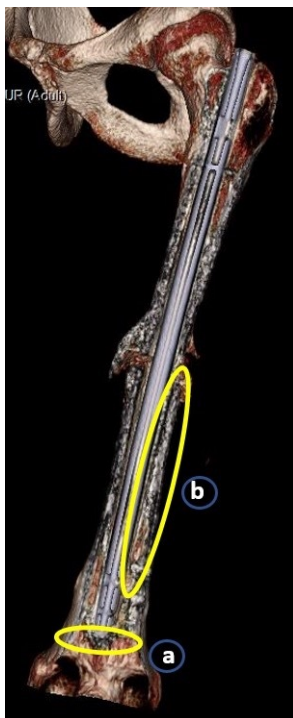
a- preoperative 3D CT showing nail tip sclerosis (corticalization); b- preoperative 3D CT showing cortex with the same density as the nail tip sclerosis.
